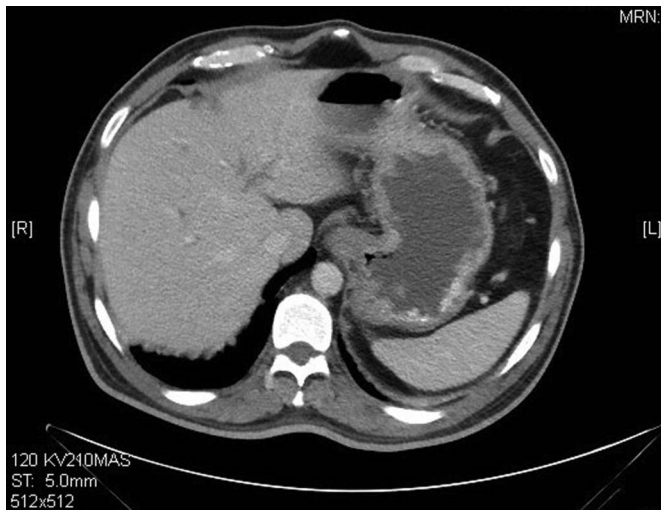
Axial abdominal computed tomography with contrast shows moderately distended stomach with moderate thickening of the wall of the stomach concerning gastric outlet obstruction.
